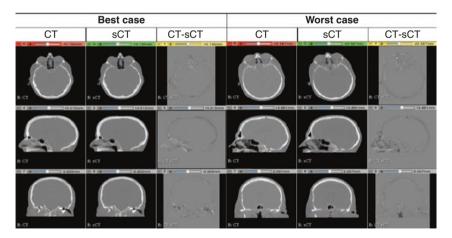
CNN-based sCT of head and neck patients; best case (left) and worst case (right). Note that CNN provides very accurate presentation of bone and soft tissue which other methods fail. Note that difference image (CT-sCT) in both cases are invisible indicative of very good quality sCT. (Adapted from Spadea et al., Int J Radiat Oncol Biol Phys, 105(3), 495–503, 2019)
